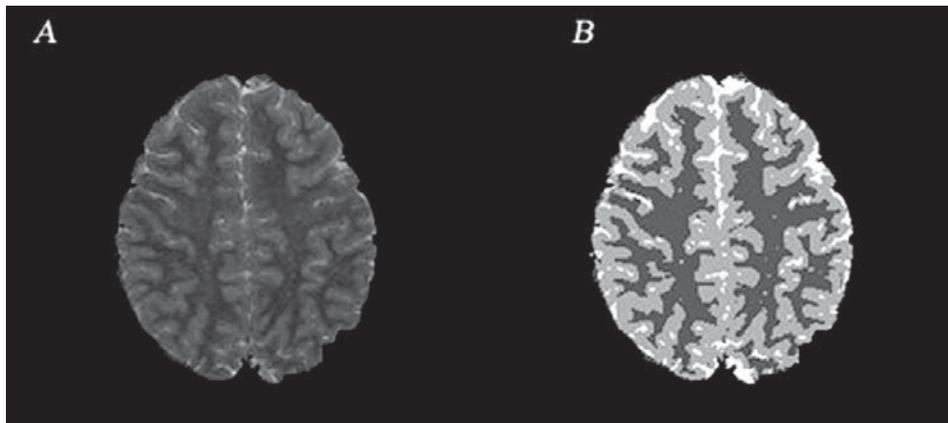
Brain tissue segmentation. A, an axial turbo spin echo T2-weighted scan for an 8-year-old child born at term, after extraction of the skull with the Brain Extraction Tool. B, brain tissue classes extracted from the image in A with the FAST algorithm. White represents cerebrospinal fluid. Light gray represents gray matter. Dark gray represents white matter
